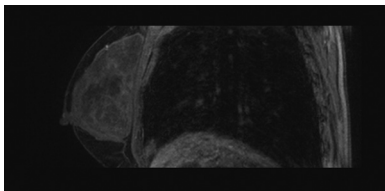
MRI showing the giant mass in the central area of the right breast, sagittally.
